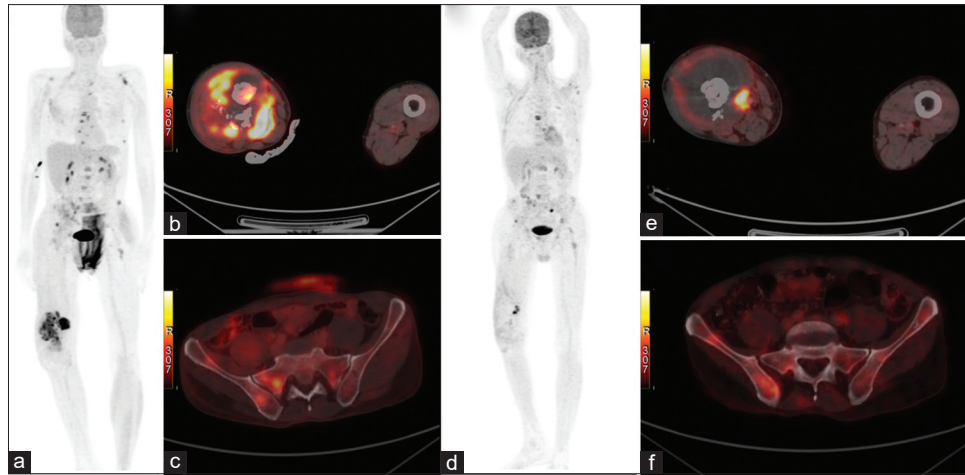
A 61-year-old male, case of primary leiomyosarcoma of right femur. (a) Whole-body maximum intensity projection (MIP) image shows heterogeneously increased fluorodeoxyglucose (FDG) uptake in the right distal femur and multiple other foci of increased FDG uptake, (b) Axial fused positron emission tomography/computed tomography (PET-CT) image showing comminuted displaced pathological fracture of the distal shaft of the right femur with increased FDG uptake and associated intensely FDG avid soft-tissue component, consistent with the primary leiomyosarcoma in this particular case, (c) Axial fused PET-CT image of the pelvis showing FDG avid subtle sclerotic lesion in the right ala of the sacrum and right ilium suggestive of metastasis. Follow-up 18-F FDG-PET-CT study performed post 6 cycles of chemotherapy, (d) Whole body MIP image, (e) Axial fused PET-CT image showing reduction of fracture with distal femur nail and regression in the extent of soft-tissue component associated with the primary lesion, (f) Axial fused PET-CT image of pelvis showing no significant interval change in FDG avidity of lesions in right ala of the sacrum and right ilium overall suggestive of stable disease
